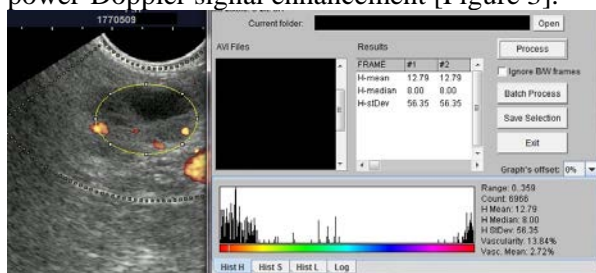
Power Doppler linear EUS and image analysis with ImageJ software – contrast enhancement can only be observed around the tumor, with low computed vascularity indexes. The cystic component can be seen in this incidence
